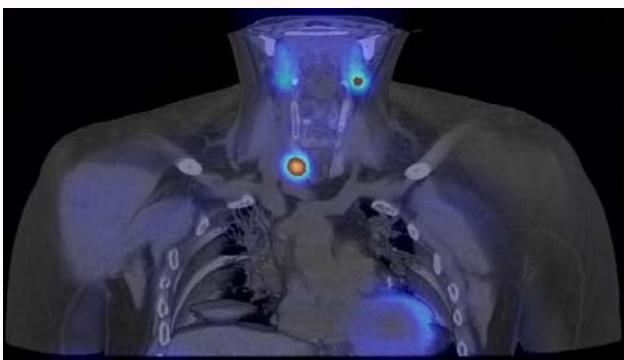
Image fusion of corresponding coronal slices of SPECT/CT demonstrates that lesion with focal increased uptake of ^{99m}Tc -MIBI is located in lower pole of right thyroid lobe.
